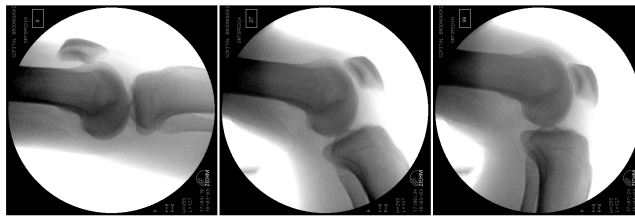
X-ray images for experimental research in knee joint kinematics
